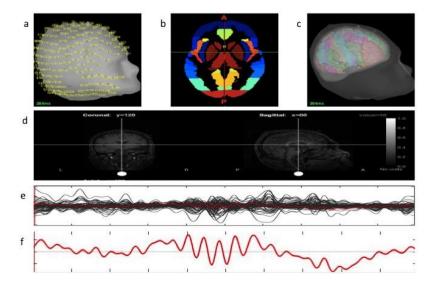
Hd-EEG data mapping on subjects.01 individual anatomical image. a) Hd-EEG cap registration on subject's scalp surface. b) Harvard-Oxford atlas. c) HOA registered MRI based individual head surfaces. d) 3T anatomical MRI used for the registration of individual brain anatomy with the atlas regions and associated electrode spikes.
